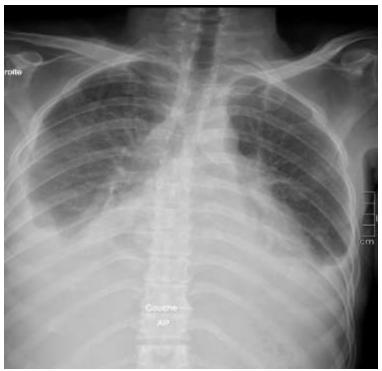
X-ray of the patient's chest showing pleuro-pericardial effusion.
